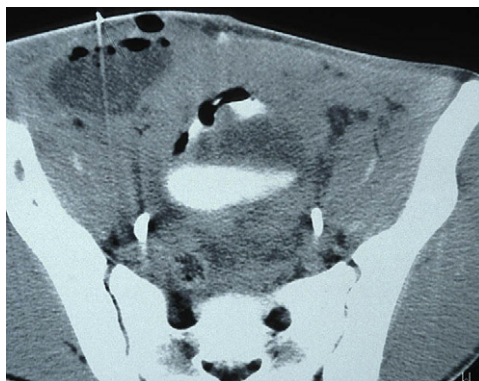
CT scan showing percutaneous drainage of Crohn's-related abscess in right iliac fossa.
